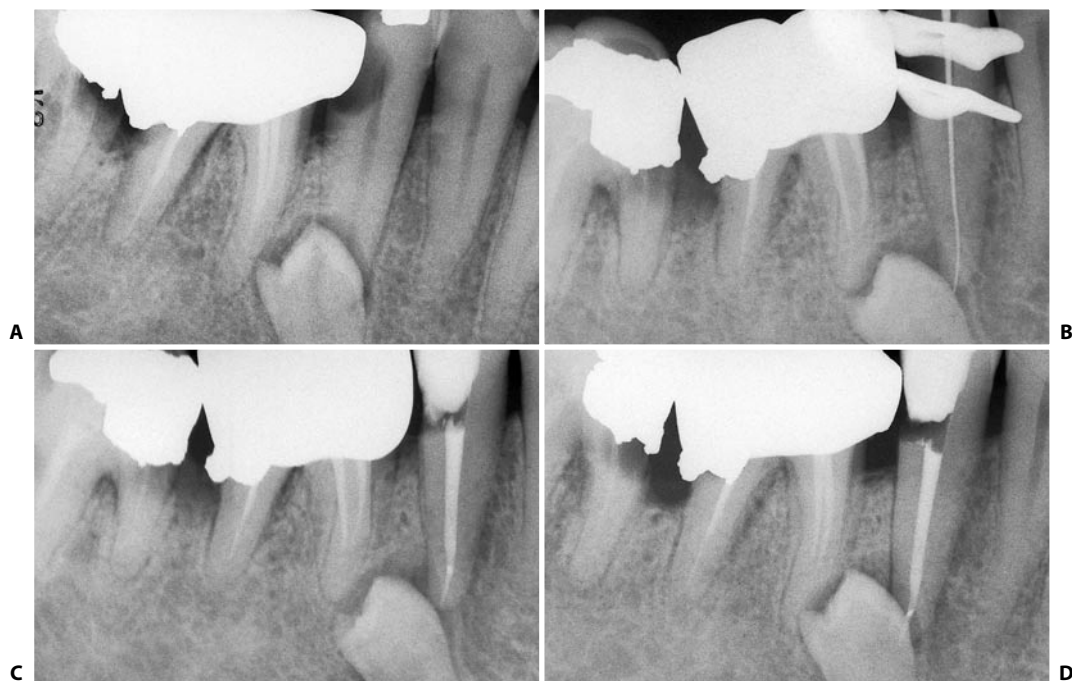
A. A supernumerary premolar hides the apex of the necrotic lower right second premolar, which is the cause of the slight buccal swelling of which the patient complained. B. A distomesial angulation confirms the lingual position of the supernumerary tooth and allows the complete visualization of the apex of the second premolar. An apico-coronal angulation has also been provided to inferiorly shift the shadow of the unerupted tooth. C. Postoperative radiograph with the same angulation. D. Postoperative radiograph with a standard angulation.
